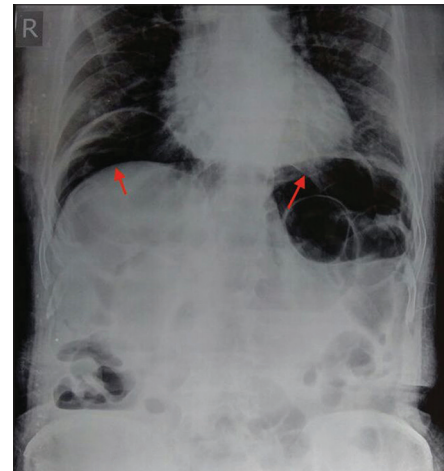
Abdominal X-ray showing subdiaphragmatic-free air (arrows)
